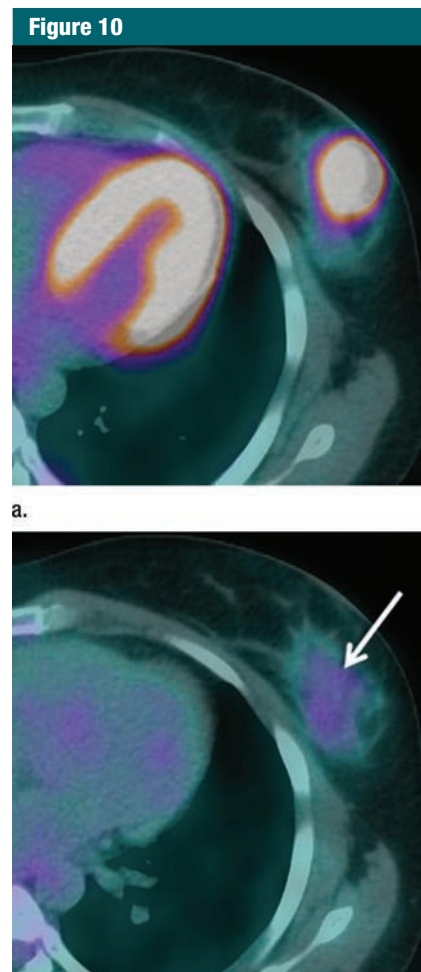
Early evaluation of NAC with FDG PET/CT (in the setting of a prospective study at Saint-Louis Hospital) in a 38-year-old woman with invasive ductal carcinoma of lower outer quadrant of the left breast. (a) Axial FDG PET/CT fusion image shows that, at baseline, SUV_{max} in the tumor was 13.6. (b) Axial image shows that, after two courses of primary chemotherapy, SUV_{max} was 2.3, corresponding to an 83% decrease (arrow). Mastectomy performed at completion of NAC (after eight courses) showed a pathologic complete response.
